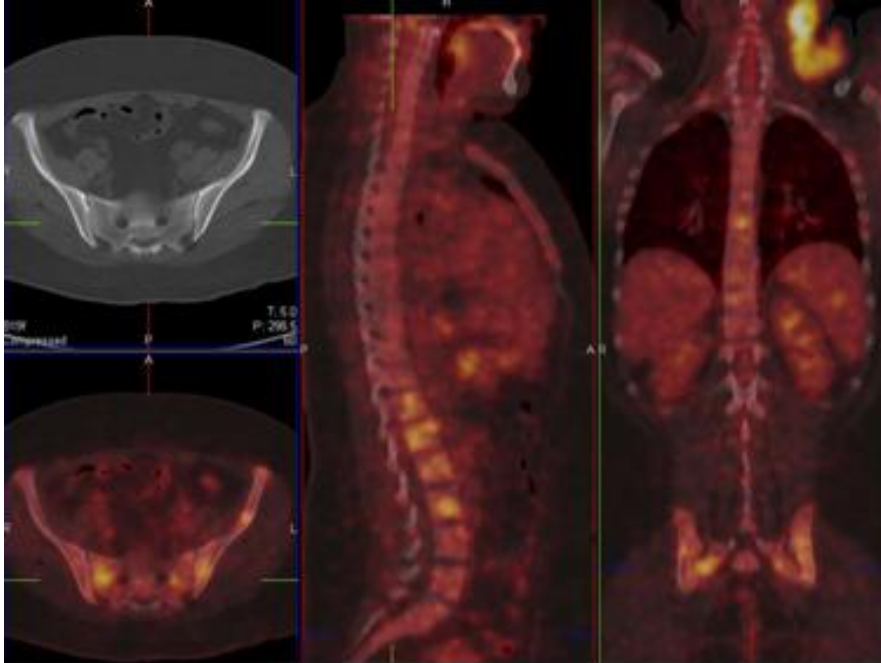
Patient C30 showing BM infiltration on FDG PET-CT in the thoraco-lumbar spine and pelvis which was not demonstrated on BMB, despite the pelvic involvement.
